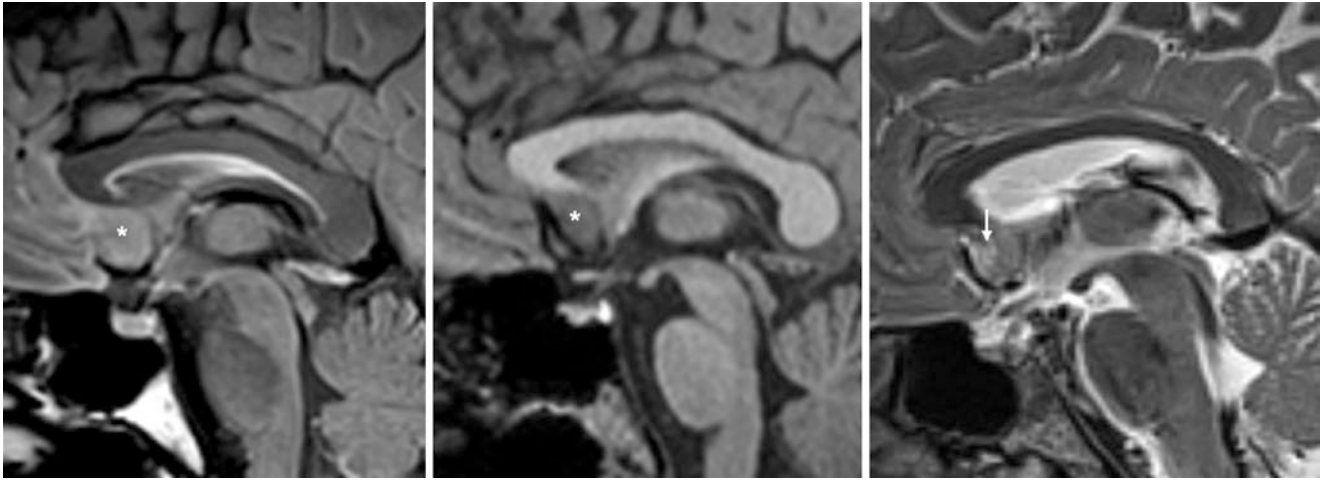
A 48 year old who had a 3T MRI performed for a research study; this demonstrates a pseudomass in the subcallosal region (*) on a midline sagittal FLAIR image (*left*). Sagittal T1WI (*middle*) and T2WI (*right*) do not confirm a mass in that region. CSF is noted (*thin*
